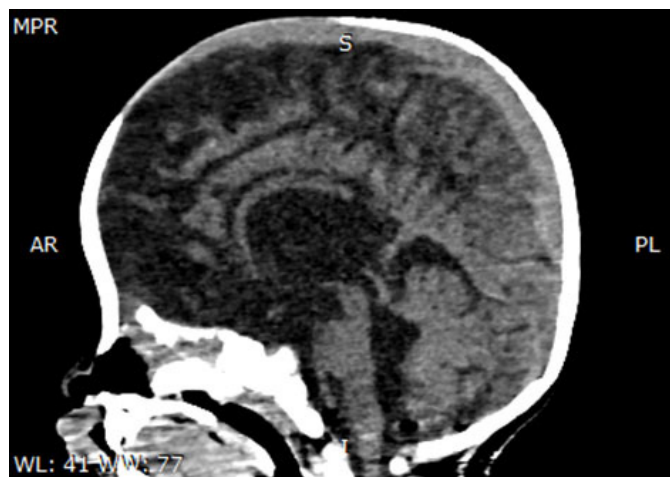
Axial view non-enhanced brain CT: Triventricular hydrocephalus due to aqueductal web.
